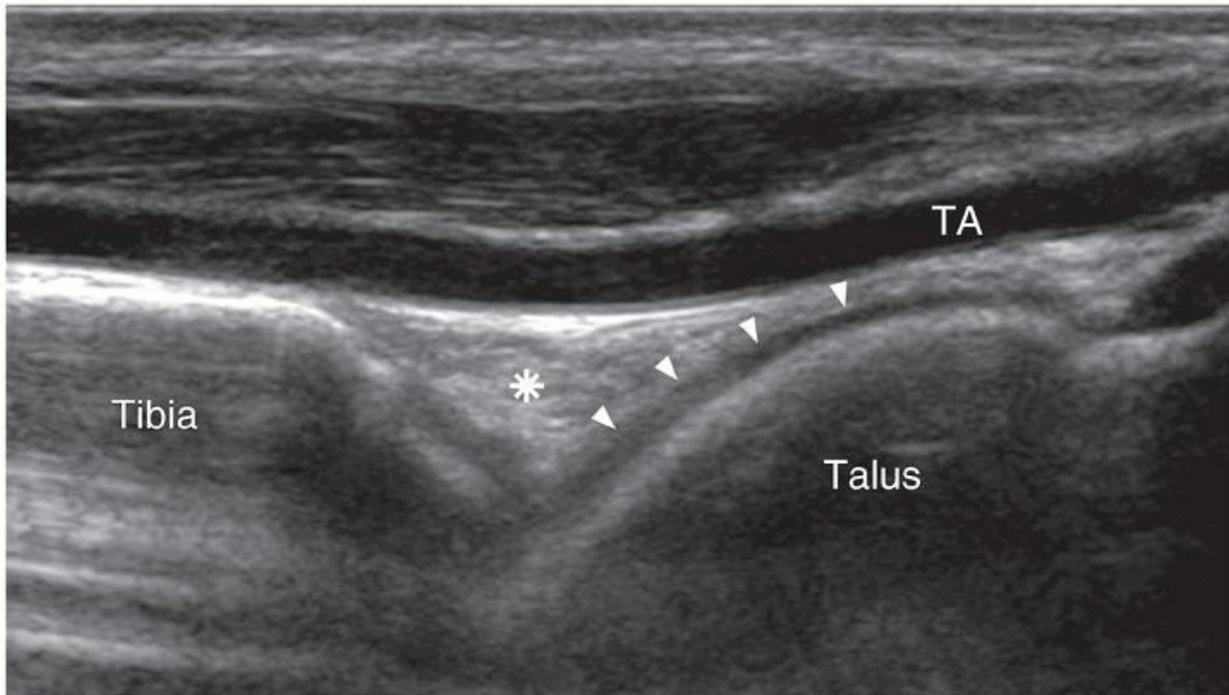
Longitudinal ultrasound of normal anterior aspect of ankle joint at the level of tibialis anterior artery (TA). Note the distal tibia and hypoechoic articular cartilage (arrowheads) on anterior aspect of the talar dome. Note the subcapsular triangular-shaped anterior fat pad (asterisk) segregating the anterior recess into smaller superior and larger inferior recesses.
